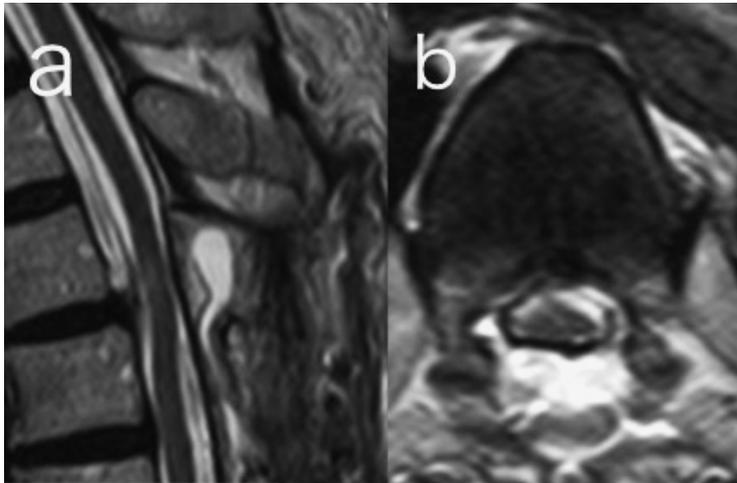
(a and b) Postoperative sagittal (a) and axial (b) T2-weighted MR images showing that the ventral displacement of the spinal cord has improved.
